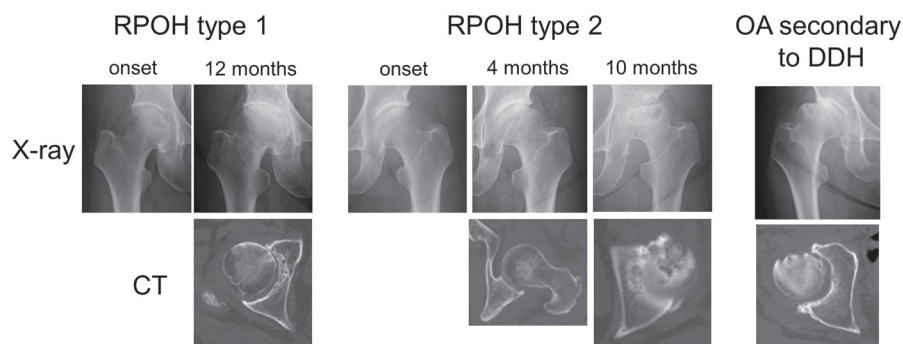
Disease progression of rapidly progressive osteoarthritis of the hip (RPOH) during 12 months after the onset of hip pain and osteoarthritis (OA) secondary to the developmental dysplasia of the hip (DDH). RPOH type 1: Right hip joint showing chondrolysis >2 mm/year in a series of radiographs without femoral head destruction or computed tomography (CT) at 12 months after the onset. RPOH type 2: Left hip joint demonstrating partial destruction of the anterior portion in the femoral head on CT at 10 months after onset following chondrolysis. OA: Right hip OA with DDH showing partial destruction of the anterior portion of the femoral head on CT at the first visit.
